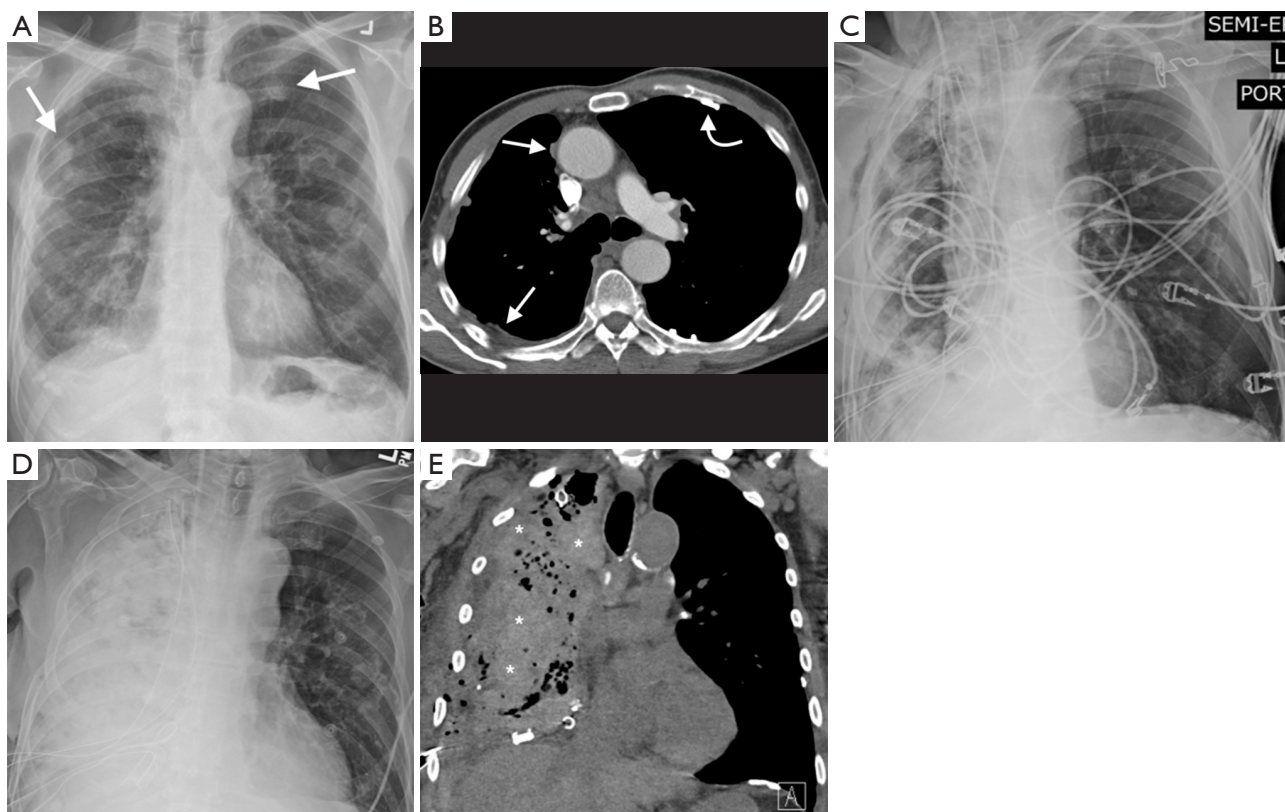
A 78-year-old man with right epithelioid mesothelioma. Initial CXR (A) demonstrates a right pleural effusion with bilateral calcified pleural plaques (arrows). Axial image from a post-contrast CT thorax (B) demonstrates volume loss in the right hemithorax with calcified pleural plaques (curved arrows) and right nodular pleural thickening (arrows); biopsy confirmed right epithelioid mesothelioma. The patient underwent right extended pleurectomy/decortication with diaphragmatic resection and reconstruction. CXR day 1 post-surgery (C) demonstrates subcutaneous emphysema in the right chest wall with 3 chest drains in situ. On day 4 post-surgery the patient's hematocrit dropped, and a CXR (D) demonstrated new, extensive opacification of the right hemithorax. Coronal image from a same-day non-contrast CT thorax (E) demonstrates extensive high attenuation material in the right hemithorax (stars) consistent with pulmonary hemorrhage. The patient underwent exploration with identification of a bleed from an intercostal vein, which was successfully ligated. CXR, chest radiograph; CT, Computed tomography.
